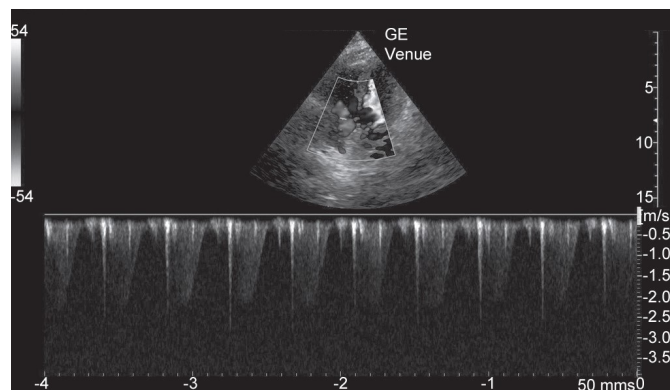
Tricuspid regurgitation demonstrated using continuous wave (CW) Doppler.
